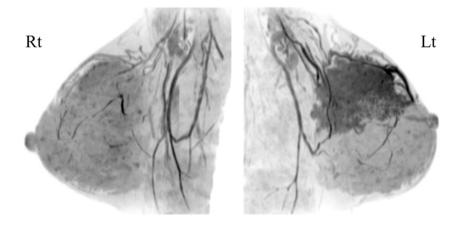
MRI Post-contrast 3D-MIP (3 days after the administration of cabergoline). Background parenchymal enhancement (BPE) was mild. Breast cancer in the upper region of the left mammary gland showed segmental enhancement.
